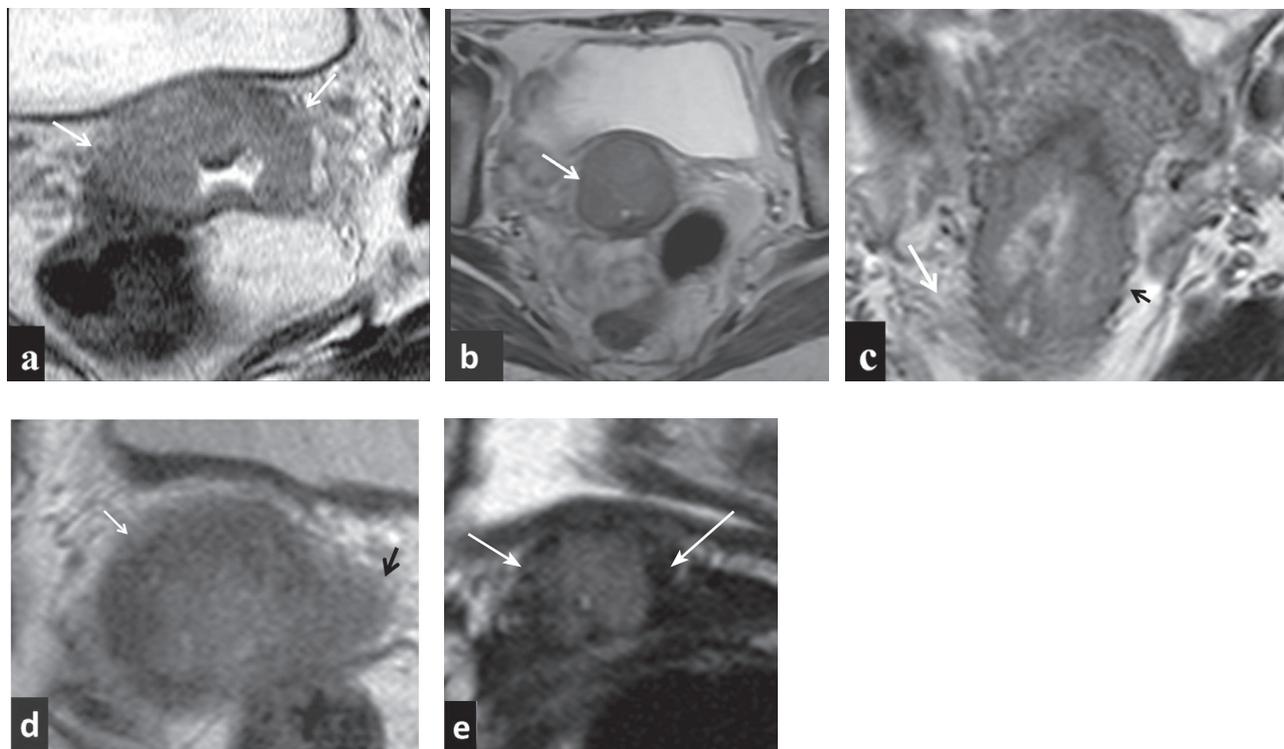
Recorded MRI T2-weighted cervical stroma appearances in patients with full stromal invasion, axial plane: (a) complete stromal disruption, (RT/LT side, arrows), (b) thin (<3 mm) but overall preserved rim (RT side, arrow) (c) thin rim (<3 mm) with tiny focal disruptions bilaterally (black arrow) and peritumoural stranding on the right side (white arrow), (d) thick but inhomogeneous rim (RT side, white arrow), tumour protrusion to parametrium (LT side, black arrow), (e) inhomogeneous rim and shaggy inner cervical border (RT side, small arrow), intact rim (LT side, long arrow).
